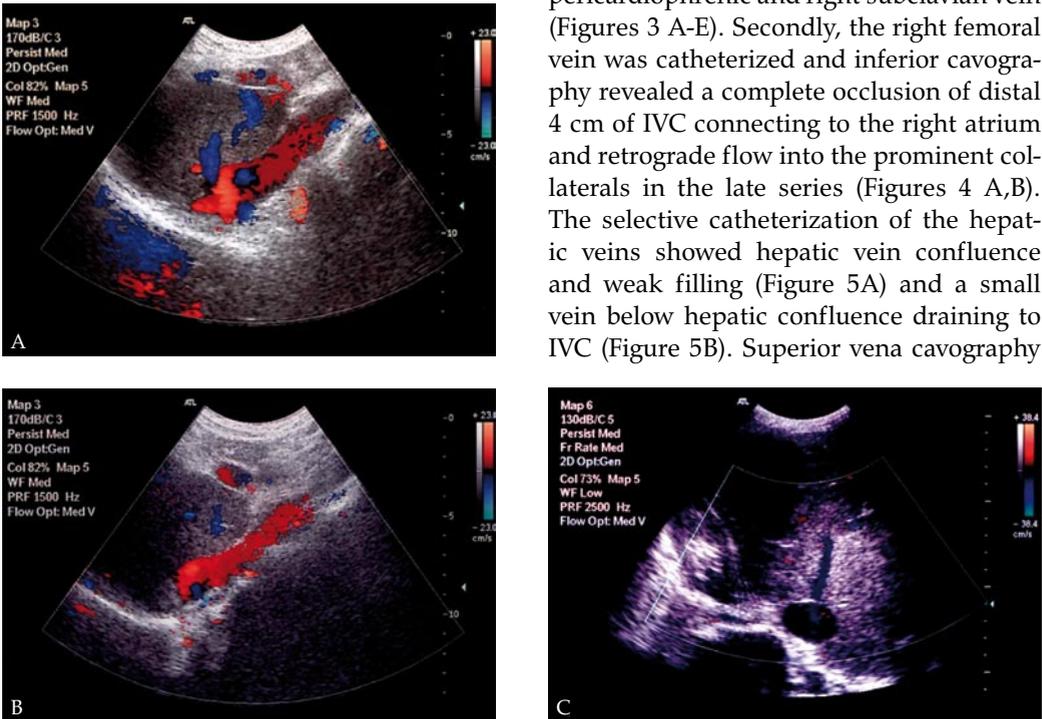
Sagittal (A, B) Doppler US images slight filling of hepatic vein and complete occlusion of distal IVC. Subcostal oblique image (C) reveals a relatively small hepatic vein below the hepatic confluence.
